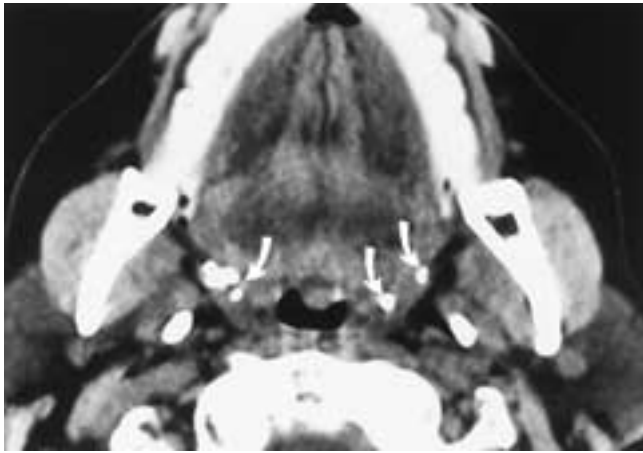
Axial CT scan demonstrates the characteristic appearance of benign tonsillar calcifications (*curved arrows*).
